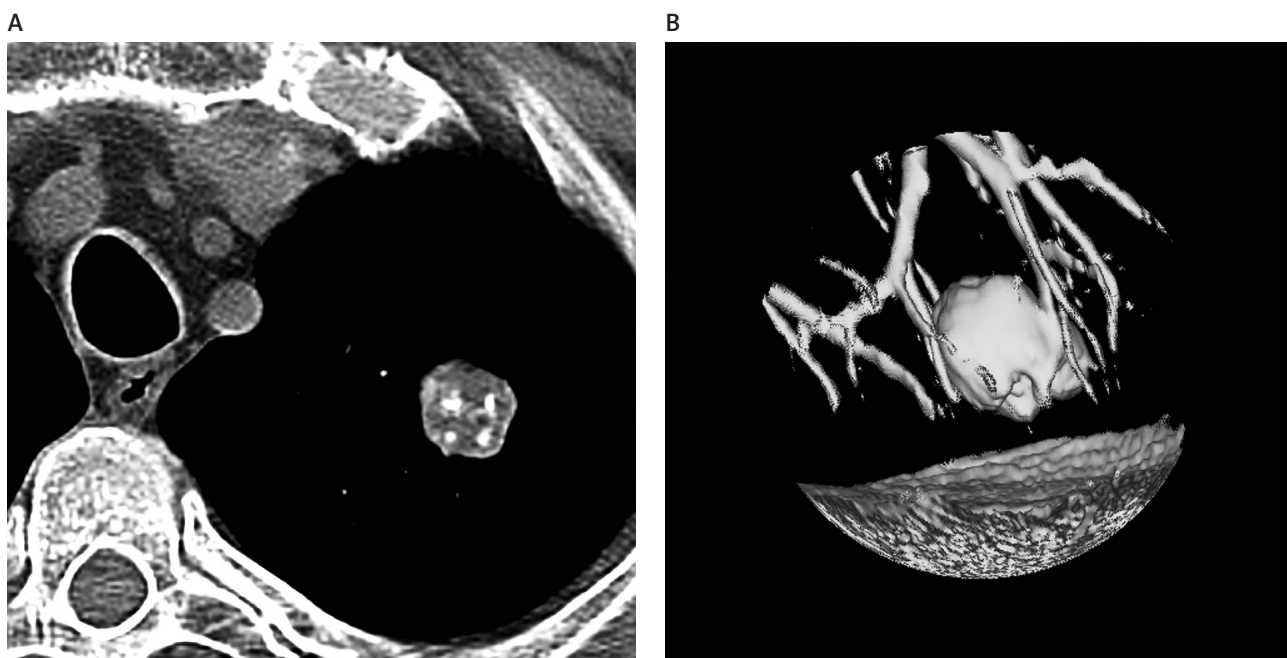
Computed tomography showed irregular tumor with characteristic popcorn pattern of calcification (A) and 3D visualization of tumor and vessels (B)
